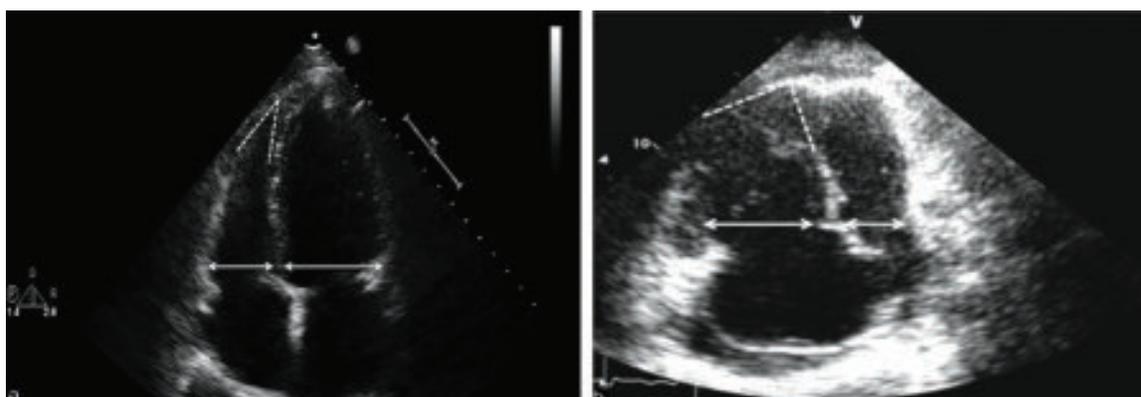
Upper panel shows Apical four chamber view. Panel A demonstrates normal RV: LV size ratio (<1.0) and shape, with a preserved acute angle of the RV apex in a patient either without PH or with pulmonary venous hypertension. Panel B represents a patient with PAH or another form of PH with pulmonary vascular disease. Note the RV: LV ratio is increased (>1.0), the angle of the apex is less acute, and the RV is apex-sharing with the LV. Lower panel shows eccentricity index in short axis (> 1.0).
